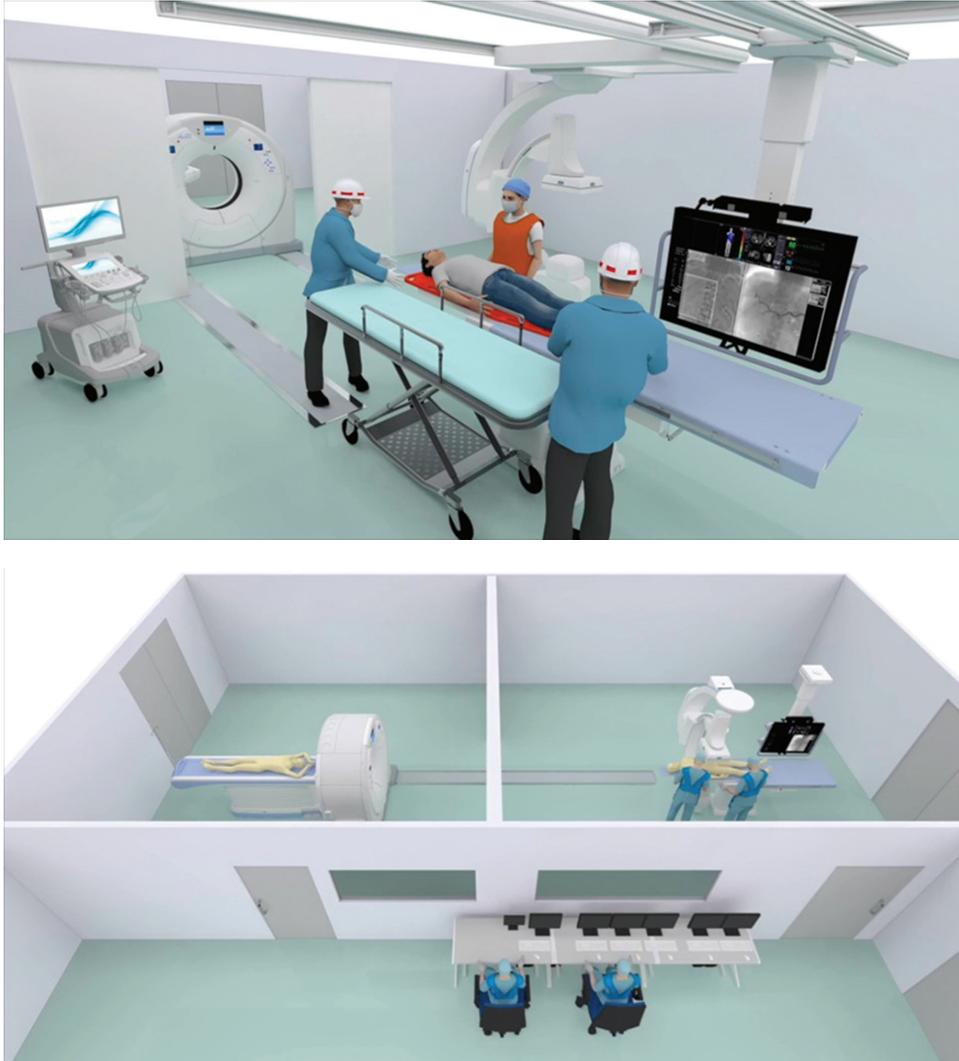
The dual room type hybrid emergency room system. (a) The patient is transferred to the angio-resuscitation room. The sliding gantry CT scanner comes from neighboring room to achieve immediate and safe scan even in a hemodynamically unstable patient. Surgery or embolization can be performed without moving elsewhere. (b) CT scan works independently in the neighboring room for other patients during the surgery or angiography.
